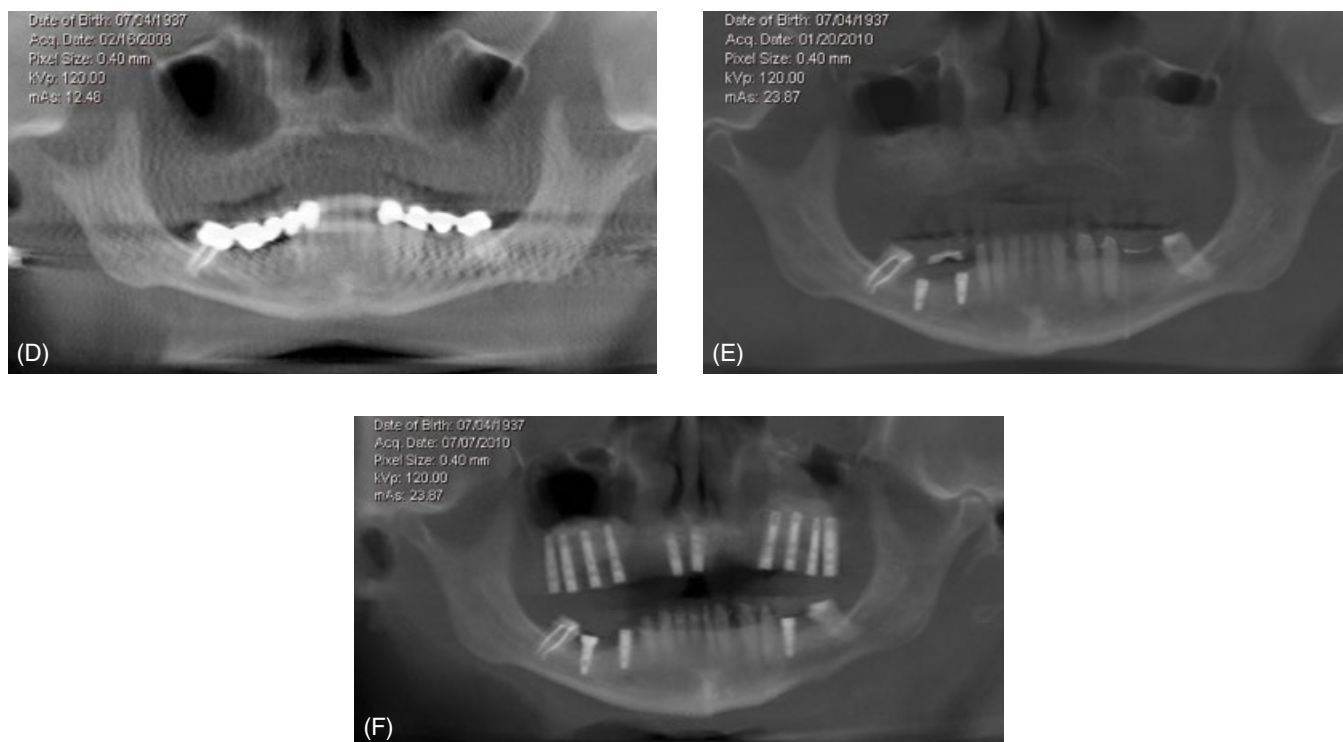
(D–F) Panoramic CBCT renderings showing before, during and after surgical treatment. Her initial clinical and radiographic evaluations revealed insufficient bone for maxillary implants without extensive grafting and reconstructive surgeries. There were no health, time, or financial restrictions.
